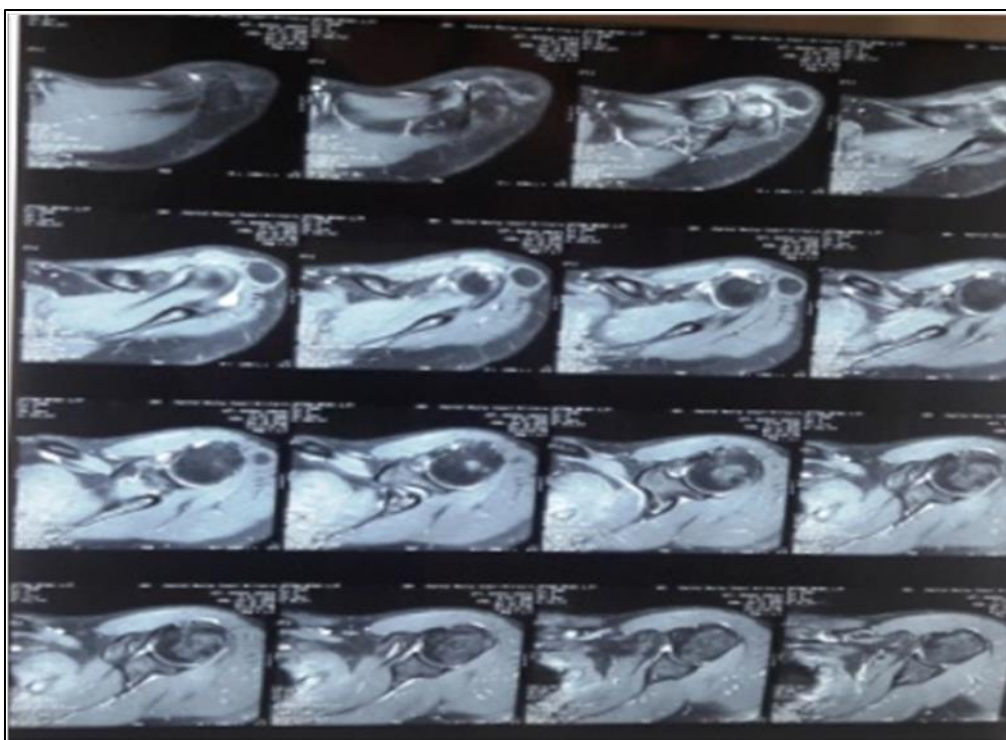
MRI showing intra-deltoid lipoma
